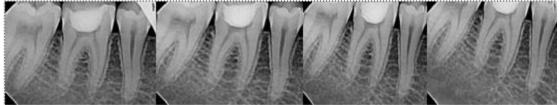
Follow up radiograph at 3, 6, 12 and 18 months
